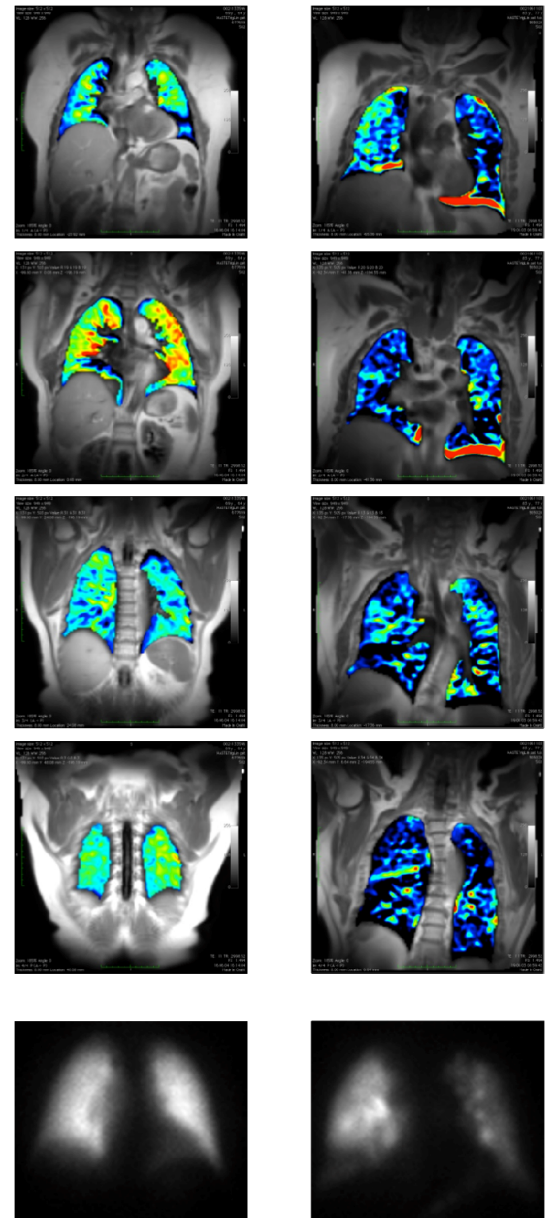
oeMRI and V-scintigraphy of healthy lungs (left) and diseased lungs (right)
